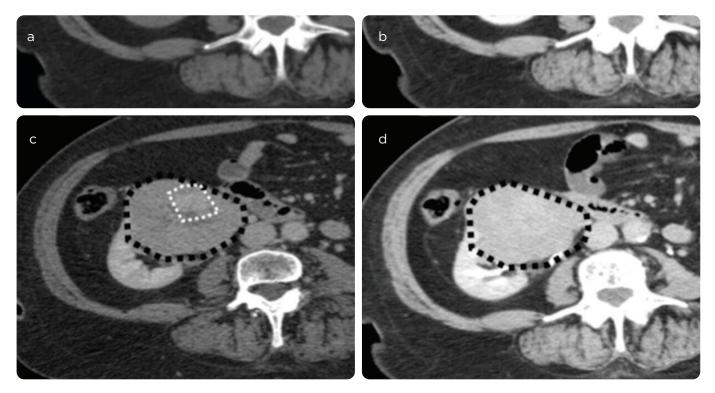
Segmental enhancement investment. CT, a) phase without contrast, b) corticomedullary, c) nephrographic and d) excretory. c) shows tumor enhancement (black dotted line), except for the central region (white dotted line). d) shows segmental enhancement inversion of the mass. The central segment in this phase is of high density with respect to the periphery, contrary to what is observed in the corticomedullary phase. In the excretory phase, the differences between the two tumor components are lost.
